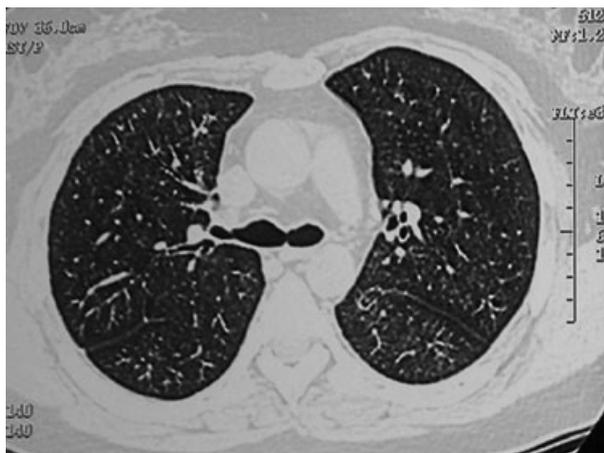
Computed tomography of the thorax showing marked improvement of the lung appearance.
